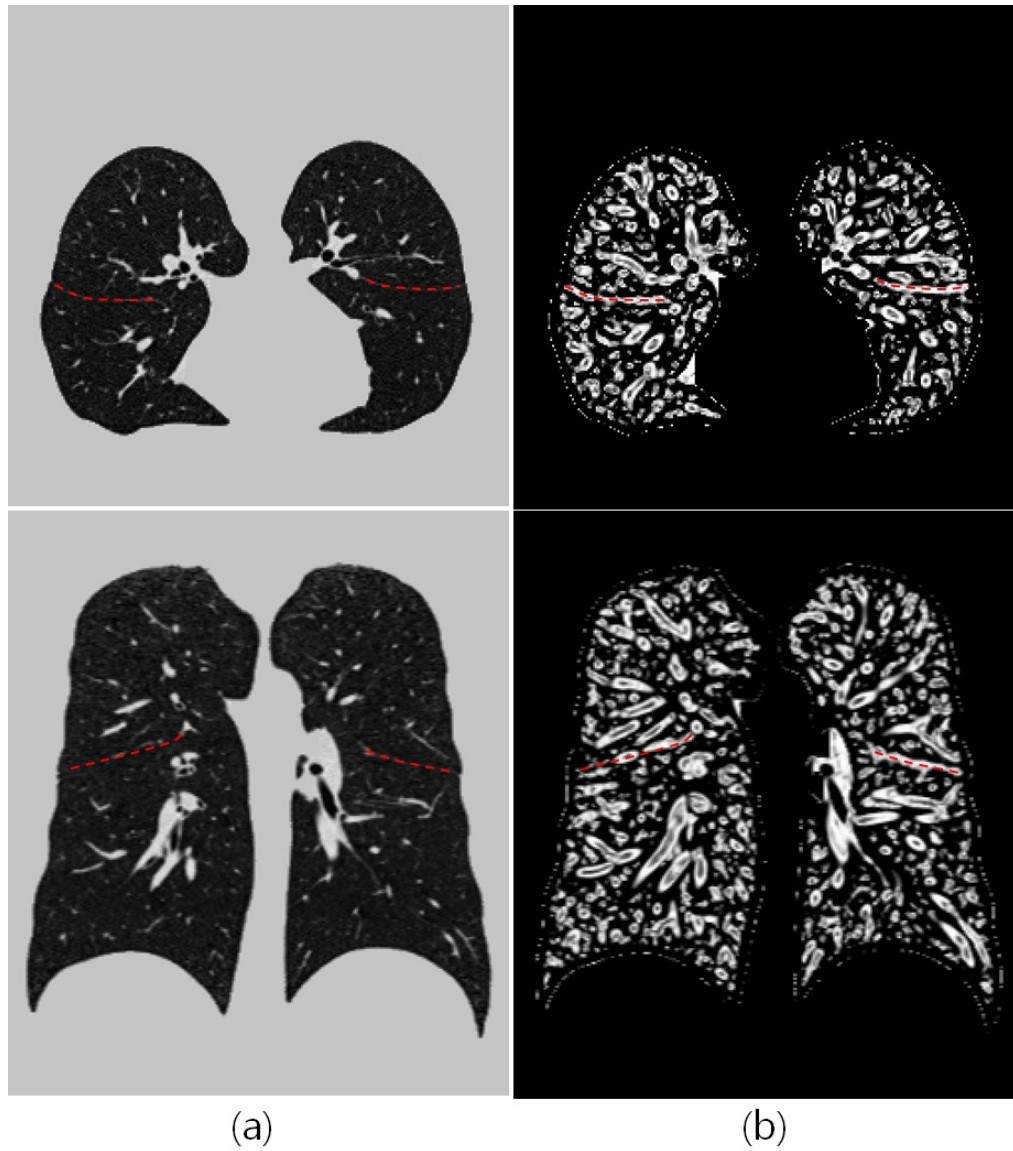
Extracted fissure-like structure in TLC. The upper row shows the transverse plane, and the lower row shows the coronal plane, (a) shows the corresponding CT image, and (b) shows the extracted fissure-like structure. The red dotted line represents the location of the fissure.
